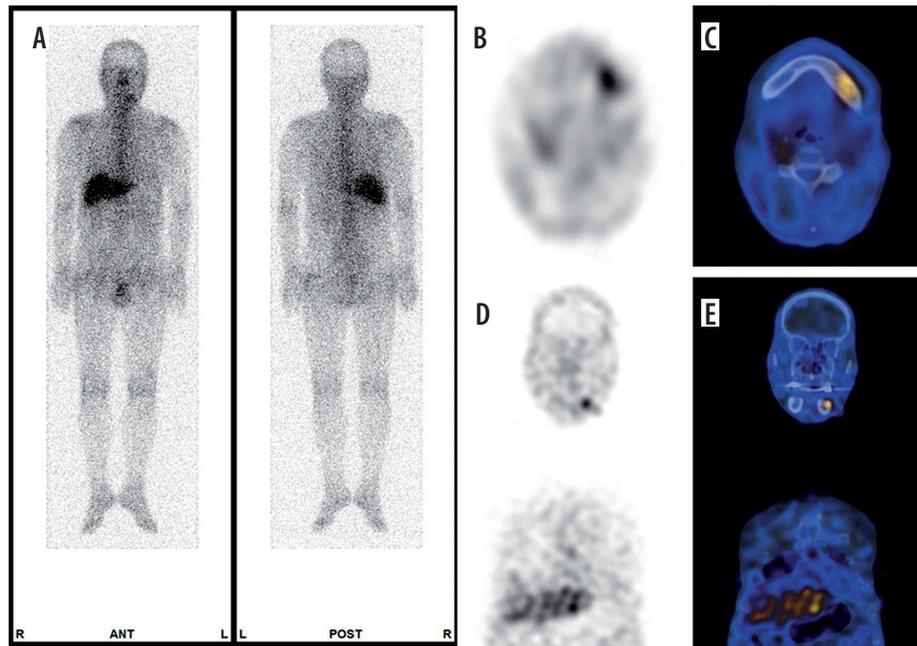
Osteomyelitis of the left side of the mandible in a 66-year-old male. A) planar, B) transaxial single-photon emission tomography (SPECT) and C) single-photon emission-computed tomography (SPECT-CT), D) coronal SPECT and E) SPECT-CT show increased uptake
